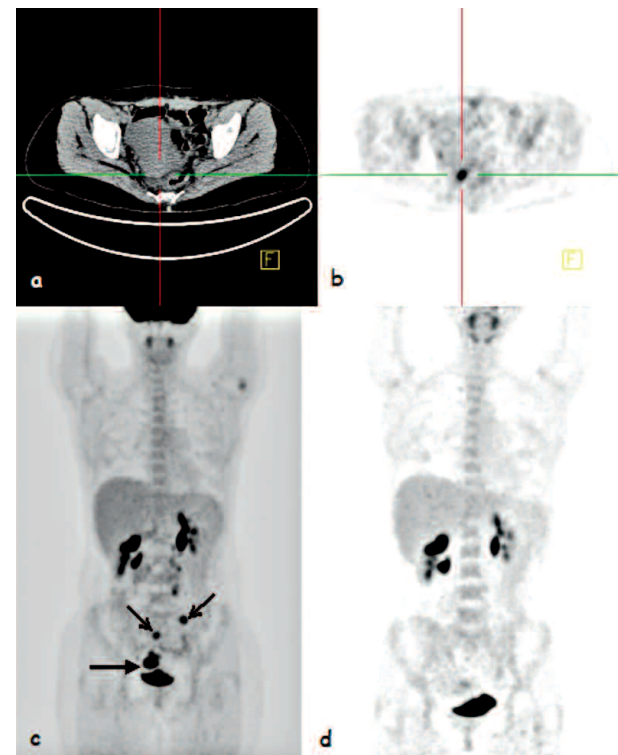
Serial ¹⁸F-FDG PET/CT examination of a 36 years old female patient with resected adenocarcinoma of the ascending colon. First postoperative ¹⁸F-FDG PET/CT scan revealed a focus of high ¹⁸F-FDG uptake in the right pararectal area (cross-bars) (a, b); Contrast-enhanced MDCT was equivocal, and CEA 5.1ng/mL. Control PET/CT scan after one year, without any treatment, demonstrated progression of local recurrence (arrow) and spread of the disease to retroperitoneal lymph nodes (c). One year after treatment by FOLFIRI and bevacizumab, PET/CT showed metabolic regression of the disease and good response to treatment (d).
